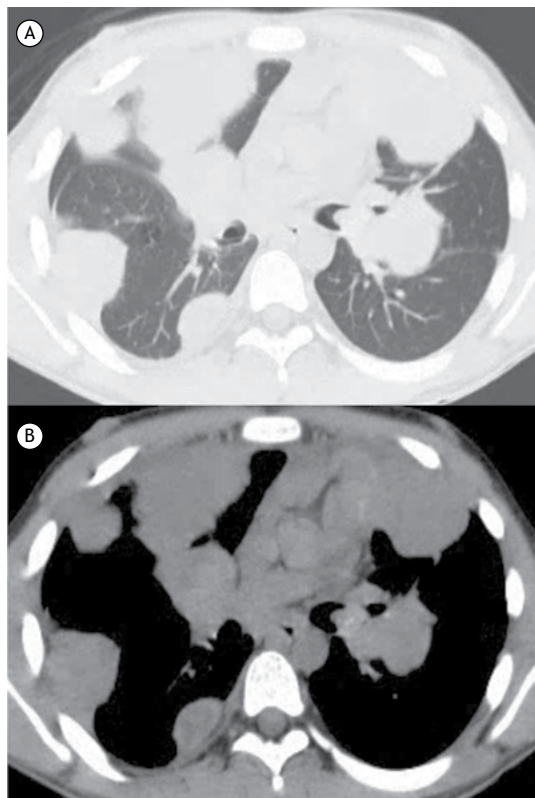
A 15-year-old boy with primary osteosarcoma of the femur. In A and B, CT scans showing multiple irregularly shaped masses in both lungs, with invasion of the left main bronchus.
